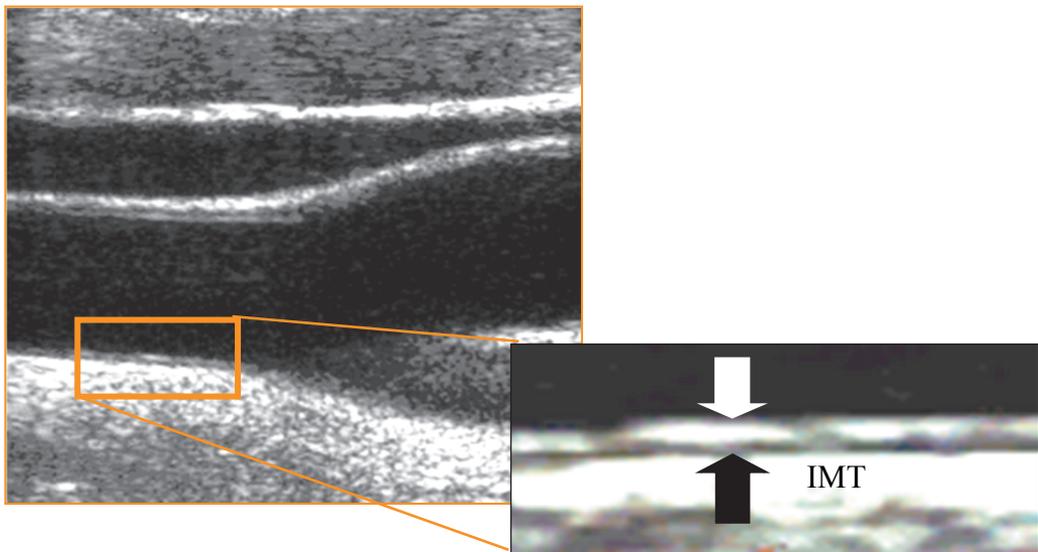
Carotid intima-media thickness. The layers between the white (lumen-intima interface) and the black arrow (media-adventitia interface) represent the intima-media layers in the ultrasound image.
